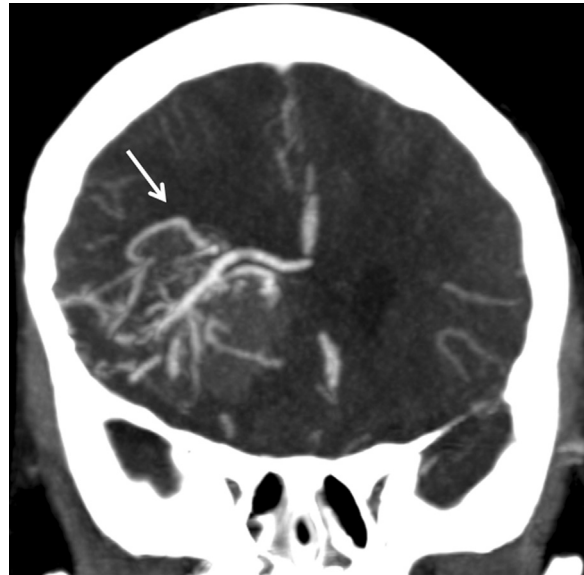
Coronal computed tomography angiography image demonstrating the high density right frontal hematoma, and the large underlying arteriovenous malformation (arrow).
